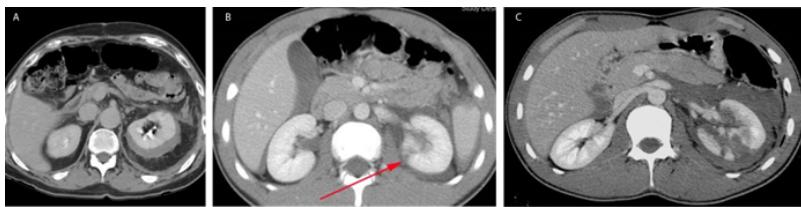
CT Scans of varying grades of left-sided blunt renal trauma (A) Grade 1 renal injury – subcapsular hematoma; (B) Grade 3 renal injury – with deep renal cortical laceration and (C) Grade 5 renal injury – shattered kidney
